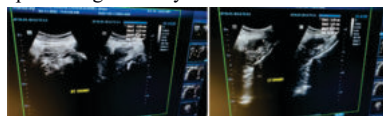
Ultrasound Pelvis After Four Months
